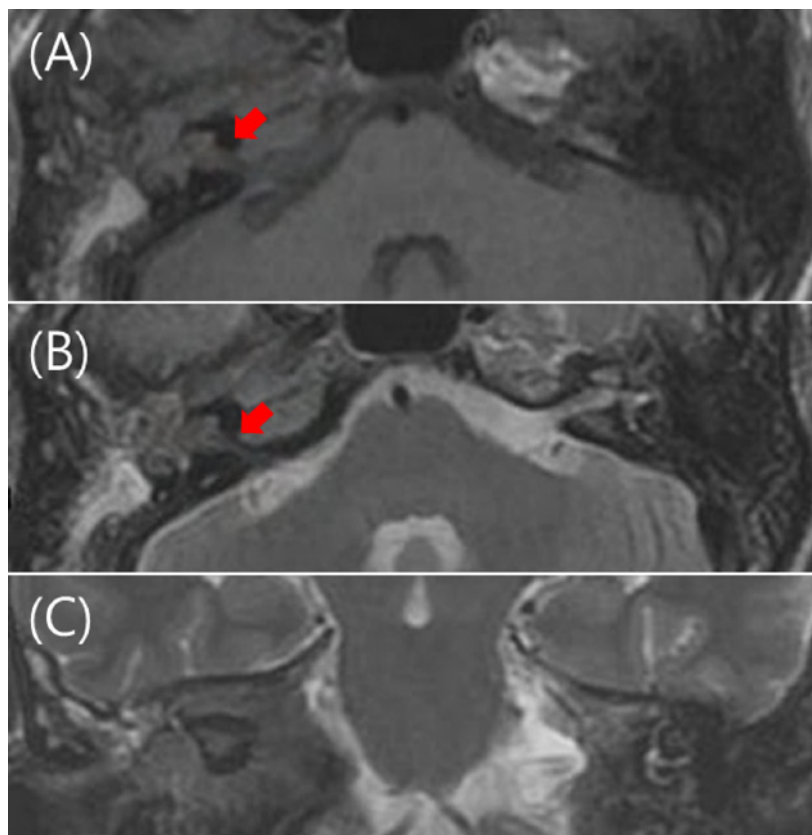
Temporal bone images. Infiltrative tumorous lesion involving inner ear (red arrows) and inflammatory lesion of the temporal bone; A: Post-gadolinium T1-weighted MR axial image; B: T2-weighted MR axial image; C: T2-weighted MR coronal image.
